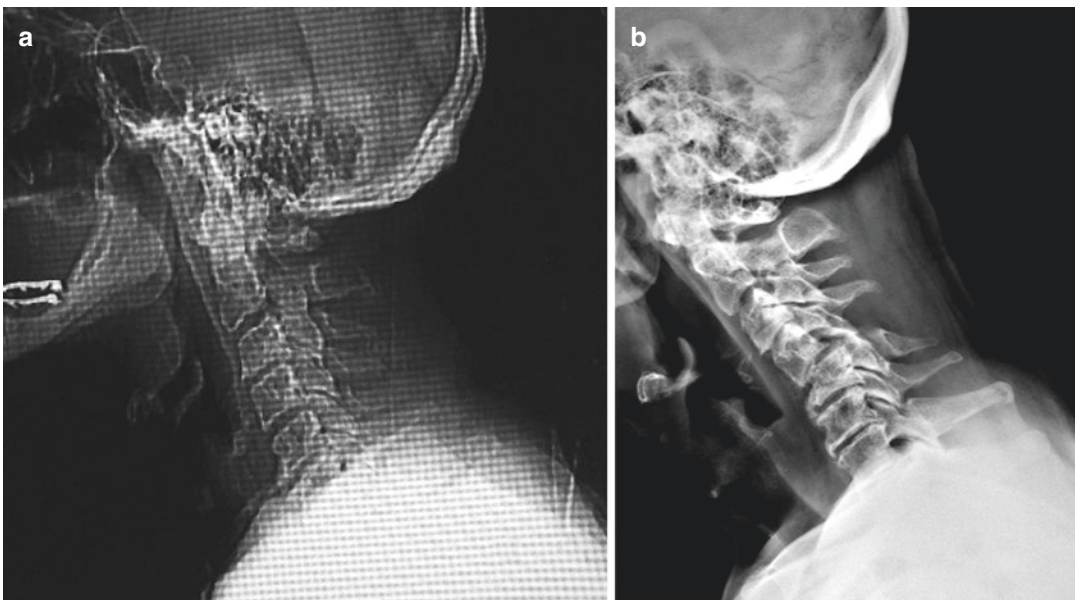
(a) CT scan normal, performed on the day of the accident; (b) cervical radiograph performed 2 months later demonstrating C4–C5 subluxation
